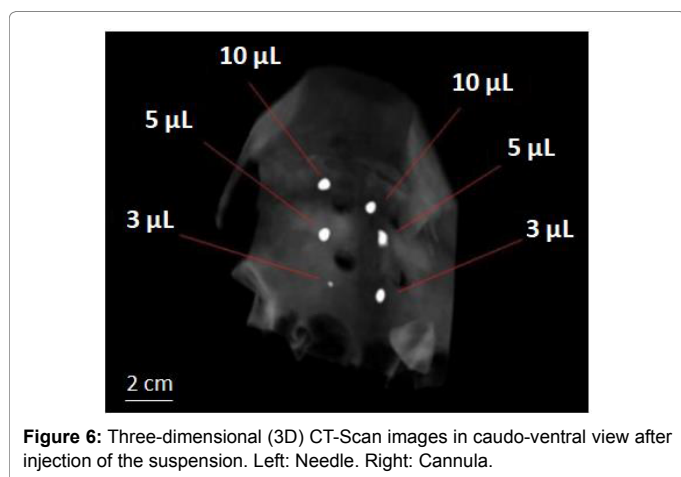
Three-dimensional (3D) CT-Scan images in caudo-ventral view after injection of the suspension. Left: Needle. Right: Cannula.
